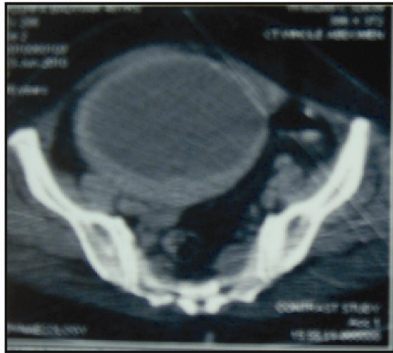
CT Scan showing a homogenous, hypodense lesion arising from the uterus.
